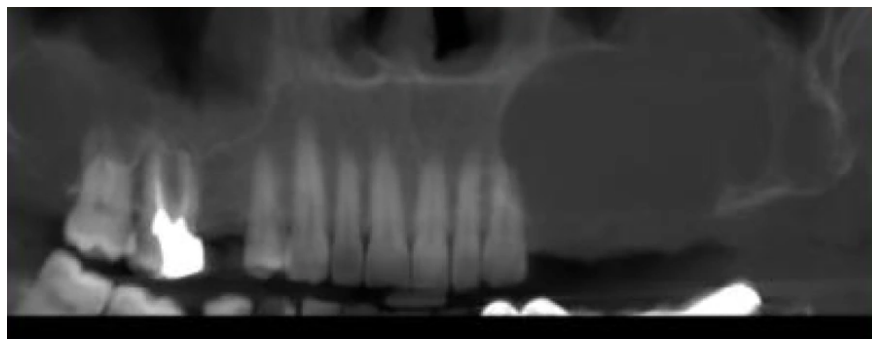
Panoramic radiograph demonstrating bilateral maxillary expansion caused by the lesion, with involvement extending across the maxillary region.
